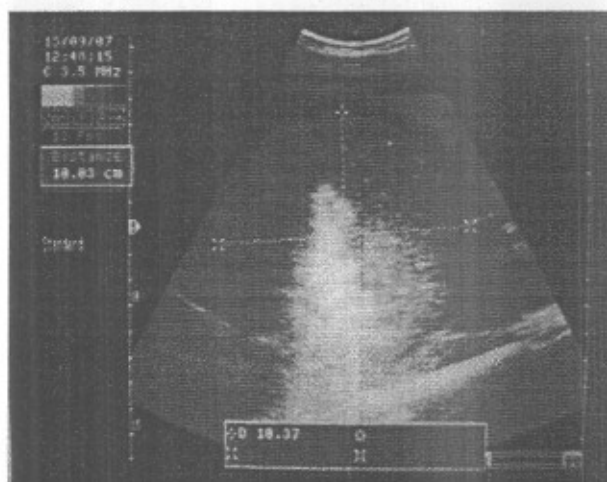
Ultrasonographic image shows circumscribed mass with echogenic capsule with hypoechoic content and present at left 4th intercostals space abscesses were presented in the thoracic cavity. Using 3.5 MHz sector probe.
